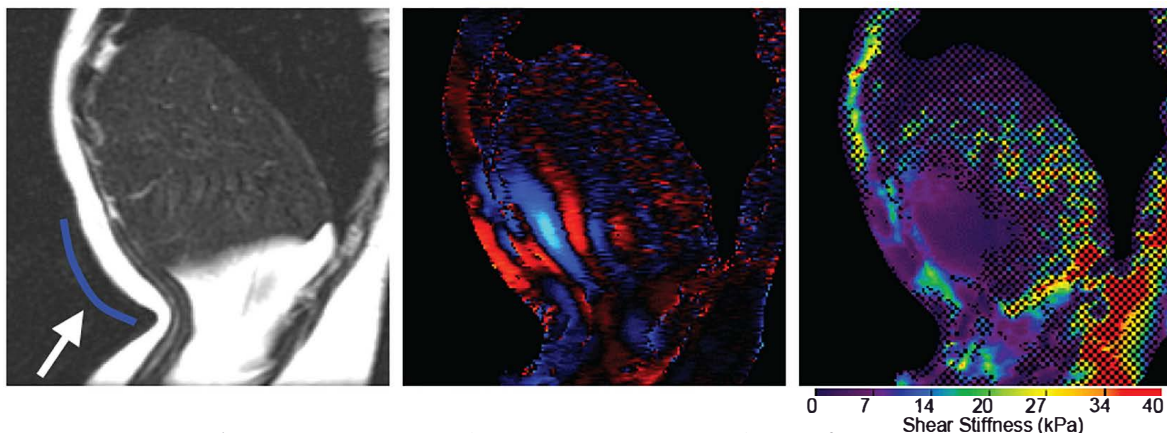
Sagittal anatomical and 50 Hz displacement images. The T2-weighted FSE image (left) shows the relative position of the passive speaker (arrow) to the liver. The wave image (center) shows the displacements propagating well into the liver. The checked areas on the LFE-derived stiffness map (right) represent regions with insufficient displacement SNR for stiffness characterization.
